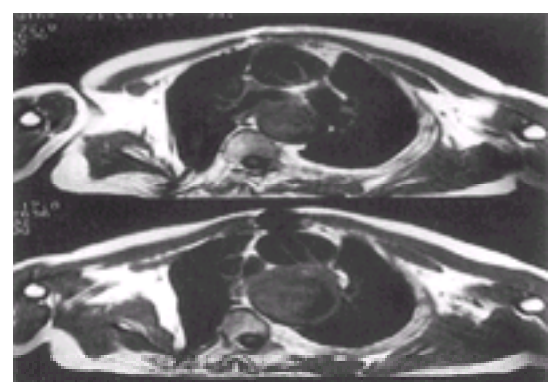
CT scan in acute type A dissection; there is an associated aneurysm of the descending thoracic aorta.
